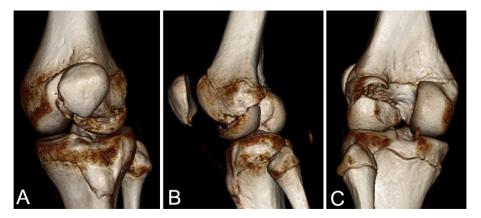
A-C) CT scan and 3D reconstruction showing the fracture of the dorsolateral fraction of the lateral femur condyle.
